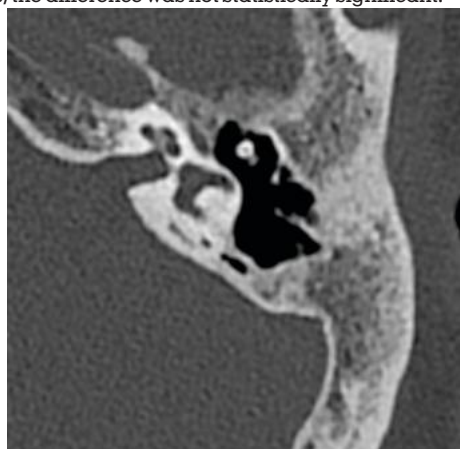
Computed Tomography Image Showing the Cylindrical Shape of the Internal Acoustic Meatus
